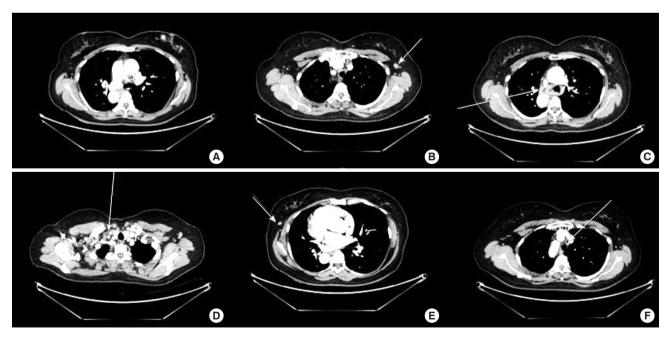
Radiologic findings for chest computed tomography (CT). CT scan shows the primary breast cancer of the left breast (A) and multiple lymphadenopathies of the left axilla (B), mediastinum (C, D), right axilla (E), and paratrachea (F). Arrows indicate enlarged lymph nodes and mass.
